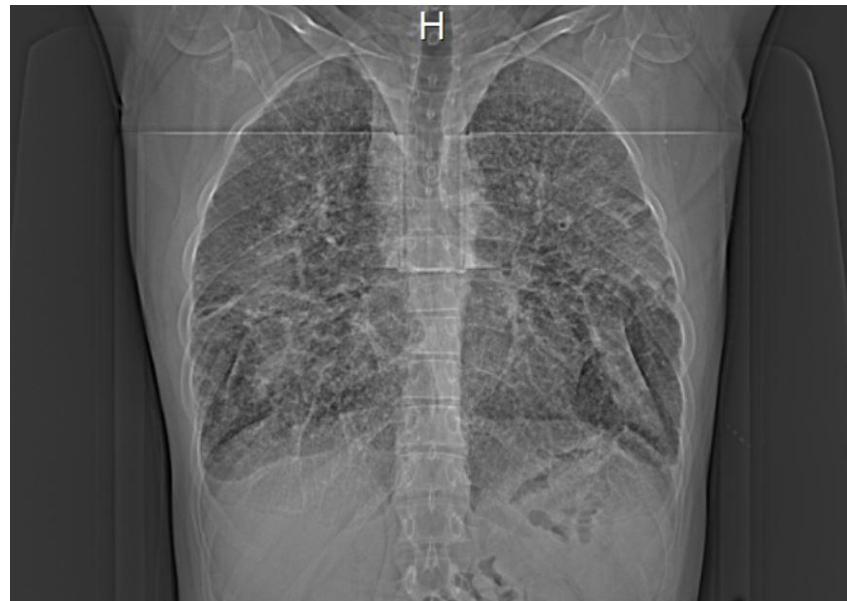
CT Topogram non-contrast demonstrating bilateral consolidation.
